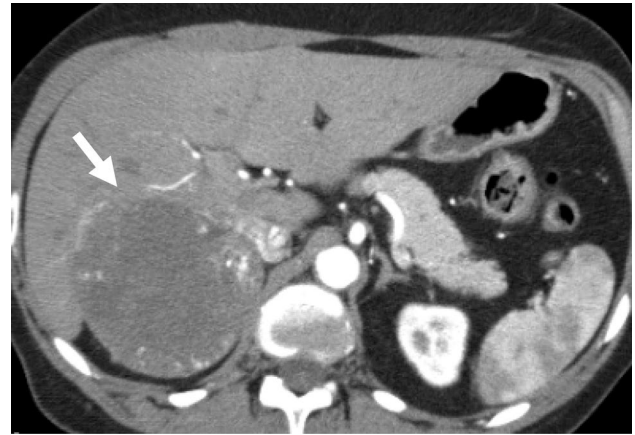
A 63-year-old female patient with incidentally discovered right large adrenal mass. Axial contrast-enhanced abdominal CT shows a large heterogeneous suprarenal mass with areas of nodular enhancement (white arrow). ACC was the suggested diagnosis radiologically. By pathology the mass lesion proved to be adrenal adenoma
